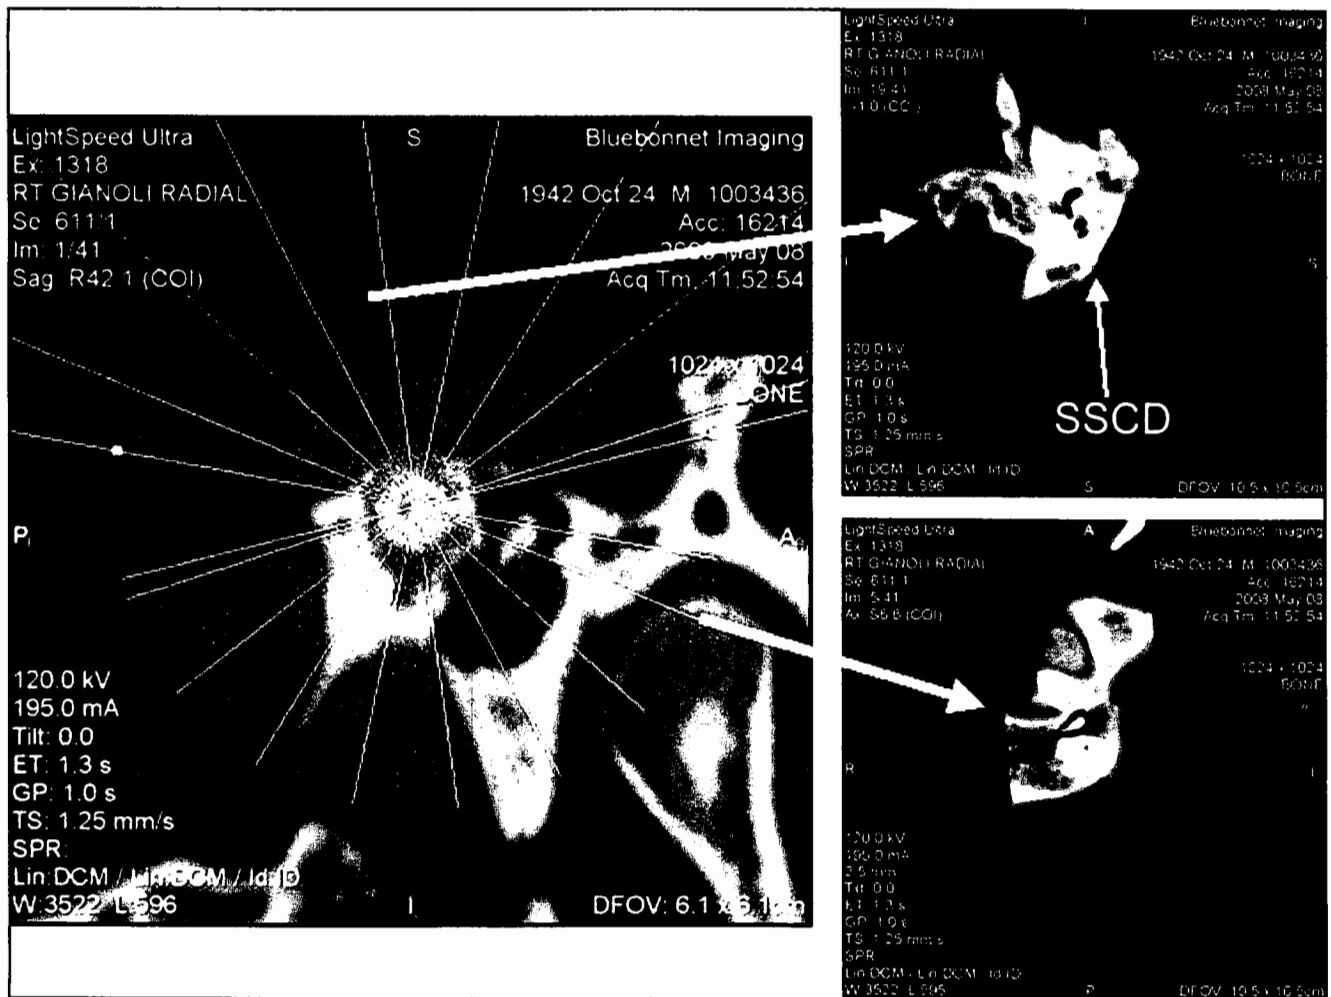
On the left, scout of CT reconstructions performed in a radial manner centered on the subarcuate artery. On the right are two corresponding slices from this construct.
